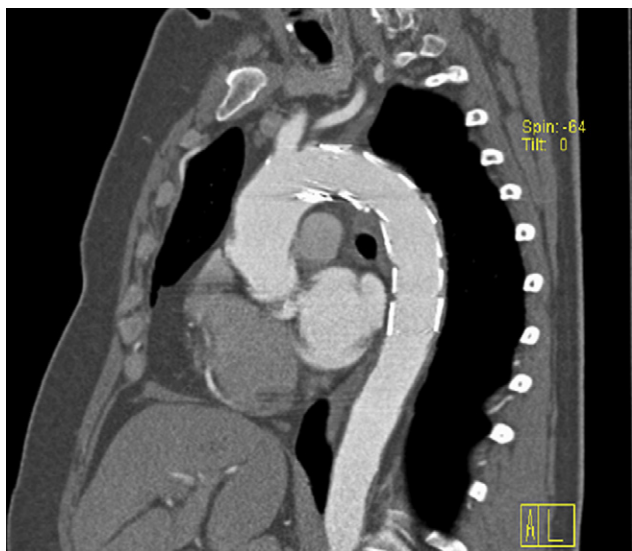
Postoperative CTA demonstrates complete occlusion of the rupture.
